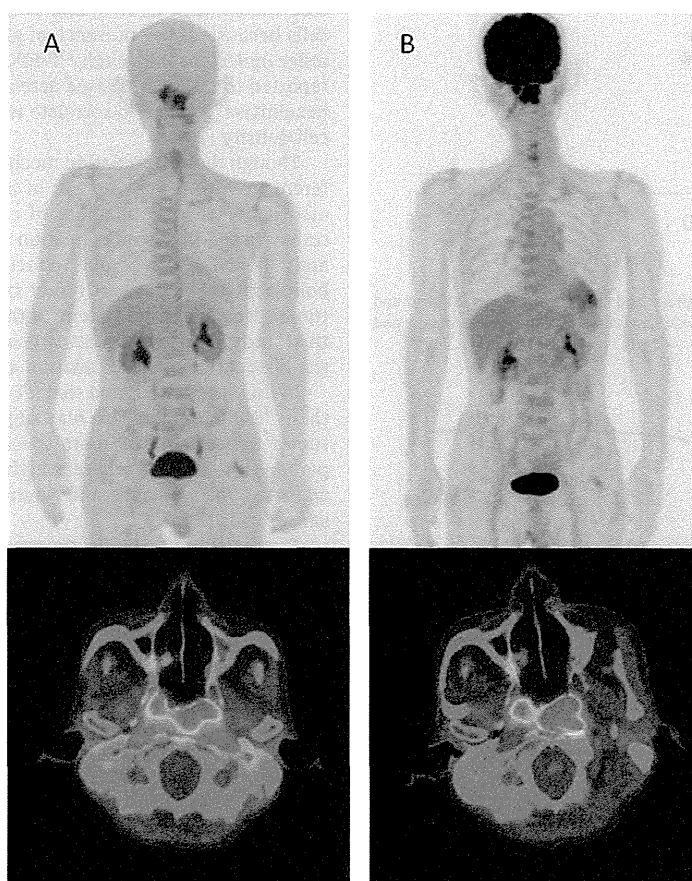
Typical ^{18}F -BPA and ^{18}F -FDG PET/CT images at 1 h after injection (Patient No. 5: 75 year-old man with epipharyngeal carcinoma). A: ^{18}F -BPA PET/CT image at 1 h after injection (SUVmax = 7.1). B: ^{18}F -FDG PET/CT image at 1 h after injection (SUVmax = 11.8). Upper panel: maximum intensity projection image; lower panel: PET/CT fusion image.
